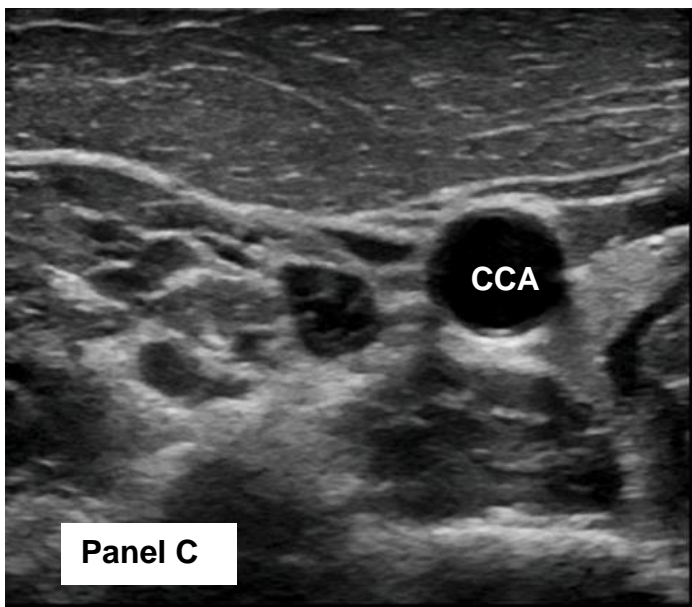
A transverse view (as shown by panel A and panel C ultrasound images) and a longitudinal view (shown by panel B and panel D ultrasound images) of the carotid artery. The two yellow lines parallel to the lumen shown in panel D, represent IMT measurements using semi-automated border-detection and quality control software. (CCA: Common carotid artery, ICA: Internal carotid artery, ECA: External carotid artery).
